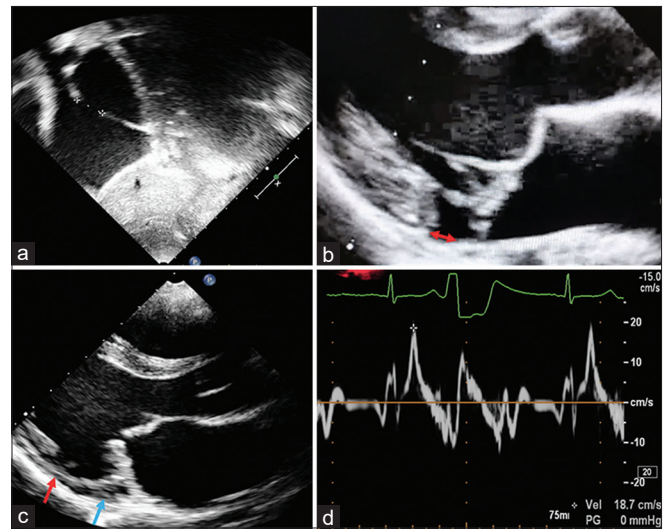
Transthoracic echocardiography of case 1. (a) Subcostal long-axis view showing the ostium secundum atrial septal defect measuring 18 mm. (b) The parastral long-axis view shows bileaflet mitral valve prolapse and the systolic displacement of the lateral hinge point of the posterior mitral leaflet (Red double arrow). (c) Parasternal long-axis view showing thickening of the posterior wall near annulus (blue arrow) and thinning of the mid posterior wall due to systolic curling of the left ventricular base (red arrow). (d) Tissue Doppler of the basal left ventricular myocardium showing a midsystolic peak of 18.9 cm/s (Pickelhaube sign)
